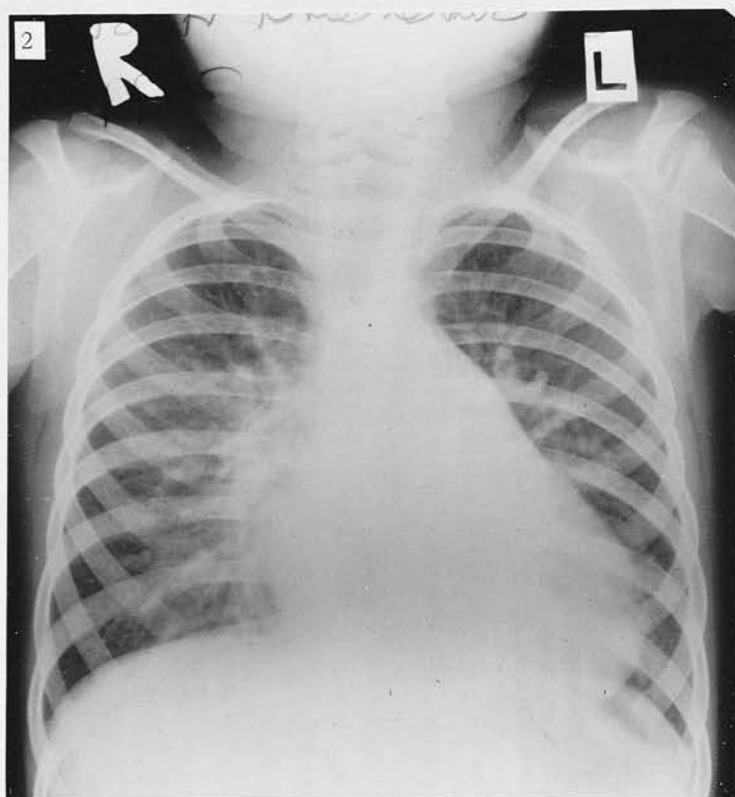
Radiograph of Case 50. Early cardiac enlargement with further increase in size during pre-school period.
